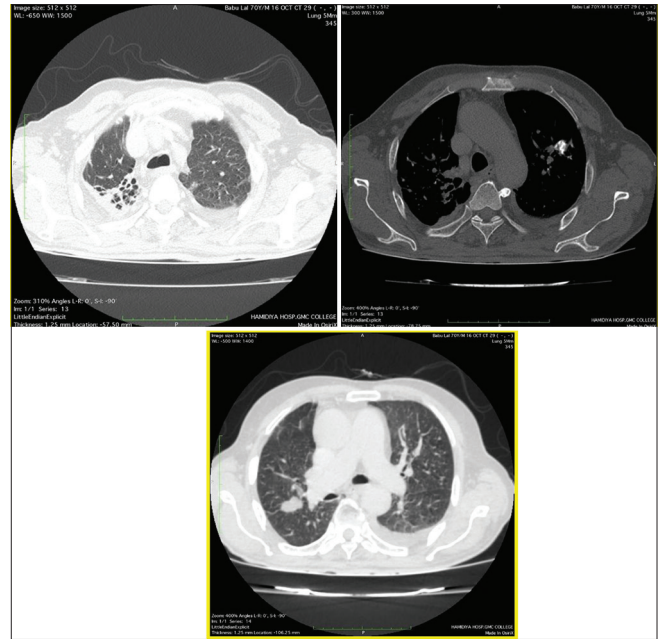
HRCT chest axial sections lung and mediastinal windows in a patients with drug-resistant tuberculosis patient showing fibrobronchiectatic changes in apical segment of the right upper lobe, calcified granuloma in anterior segment of the left upper lobe, and nodules in posterior segment of the right upper lobe along the oblique fissure
